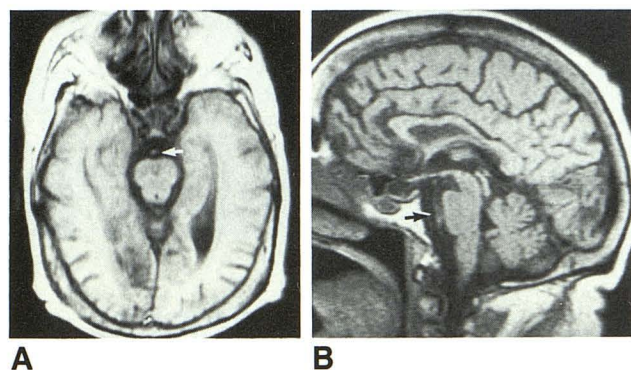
A and B, Axial (A) and sagittal (B) T1-weighted MR images, 500/28, show increased signal in basilar artery (arrow) and hypointense signal in occipital lobes.
